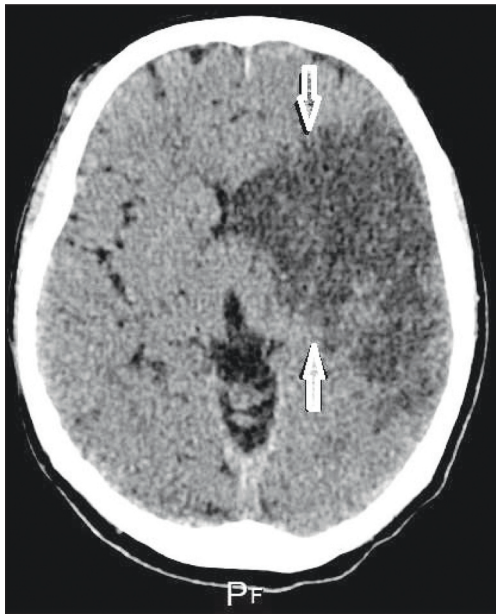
CT of brain Temporoparietal ischemic stroke with a compressive effect on the left lateral chamber
